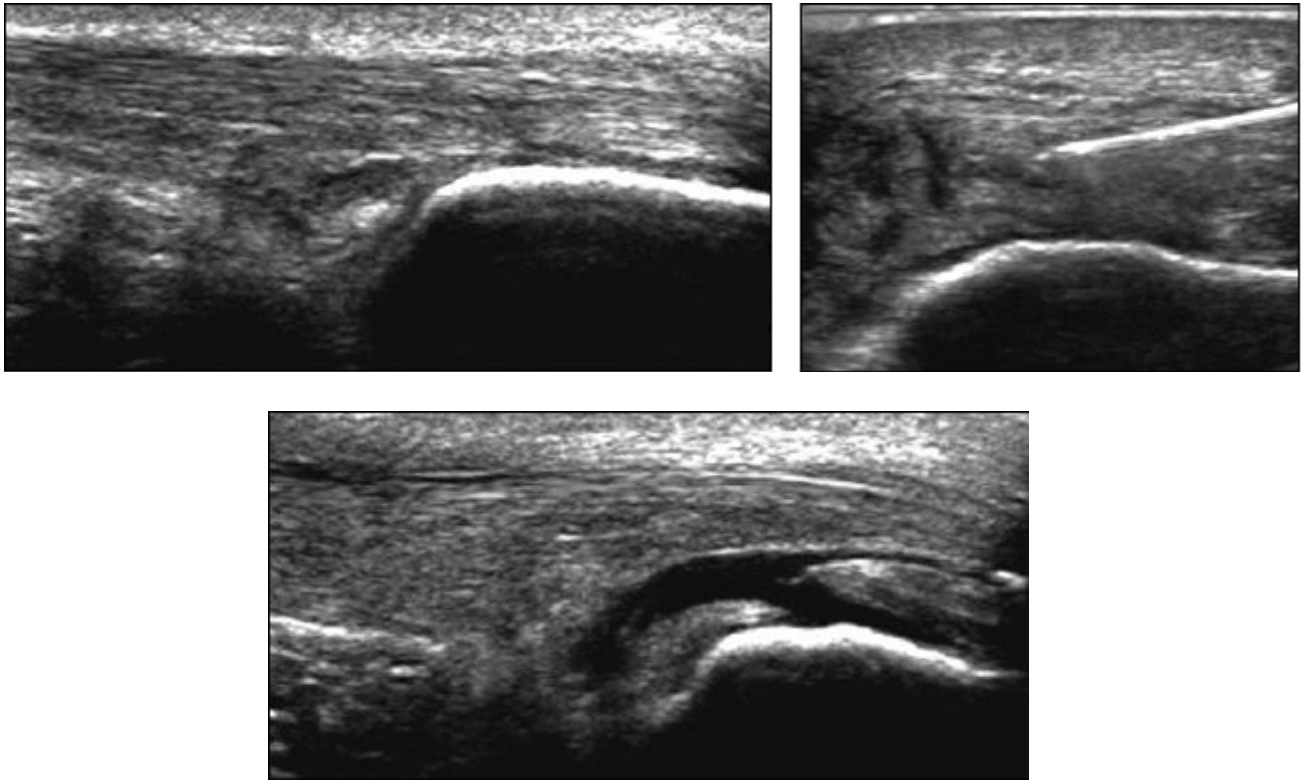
49-year-old man with insertional Achilles tendinosis. A, Sonographic image shows typical appearance of insertional tendinosis. B and C, Sonographic images obtained after single hyperosmolar dextrose injection into distal thickened portion of tendon show large bursal-surface partial thickness tear that has opened up. This patient was withdrawn from study and referred for surgical consultation.
